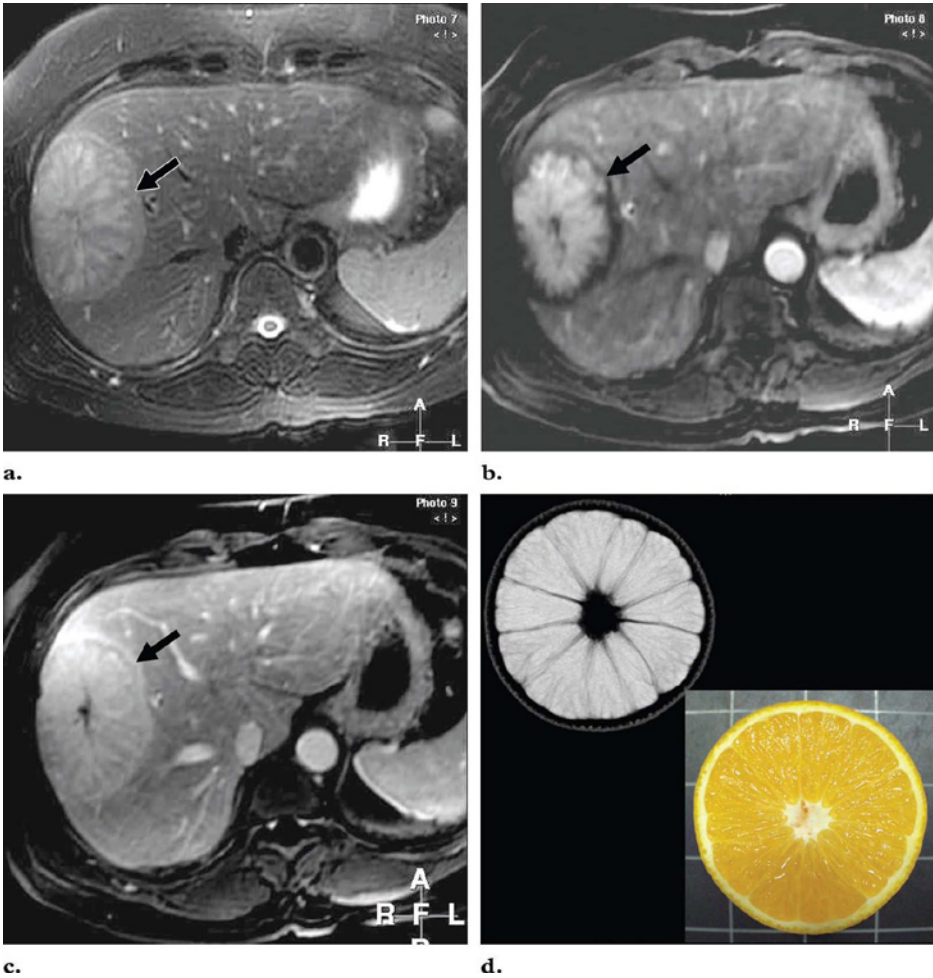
MR imaging appearance of an FNH lesion with a low-signal-intensity scar and a pseudocapsule. a. Axial fat-saturated T2-weighted fast SE image shows a predominantly high-signal-intensity FNH lesion with a spinning wheel appearance due to the presence of radiating septa and a pseudocapsule (arrow). b. Axial gadolinium-enhanced fat-saturated 3D GRE image obtained during the arterial phase shows intense enhancement of most of the central part of the lesion (arrow). c. Axial gadolinium-enhanced fat-saturated 3D GRE image obtained during the portal phase shows nearly homogeneous enhancement of the lesion, including the pseudocapsule (arrow). The lesion has become nearly isointense relative to the surrounding liver tissue. d. Axial T2-weighted fast SE image and corresponding photograph of an orange show a striking similarity to the FNH lesion.
